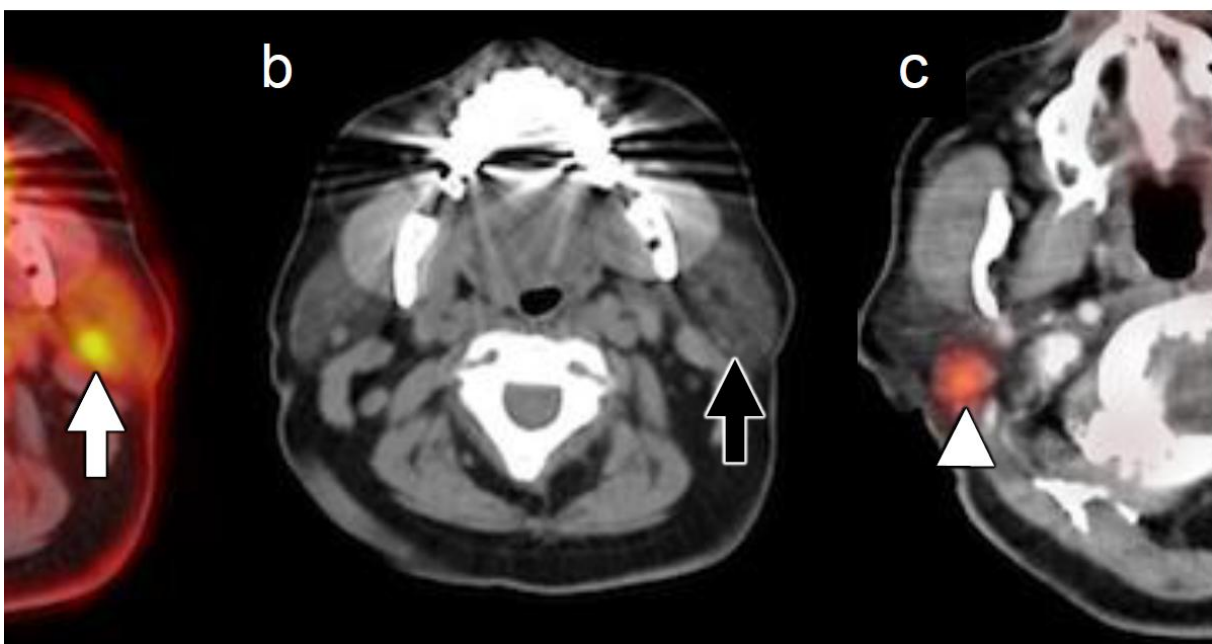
Focal salivary gland FDG uptake. Fused axial FDG-PET/CT (a) shows a small focus of increased FDG uptake within the left superficial parotid gland (white arrowhead). Axial CECT (b) in the same patient shows a subtle idodense/isoenhancing nodule (black arrow) in the superficial parotid. Ultrasound-guided biopsy demonstrated poorly differentiated carcinoma. (c) Fused axial FDG-PET/CT (c) in a different patient with breast cancer presenting for initial staging demonstrates a small FDG avid mass within the right superficial parotid gland (white arrowhead). Axial CECT of the same patient (d) shows a corresponding enhancing mass within the right parotid gland (black arrowhead) corresponding to the focus of increased FDG uptake. Ultrasound-guided biopsy of the lesion demonstrated pleomorphic adenoma.
